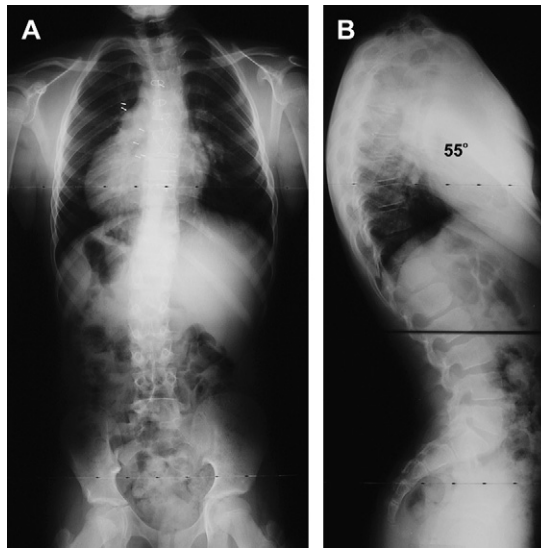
(A) Anteroposterior and (B) lateral radiographs of a patient with postural kyphosis demonstrate a uniform rounding of the thoracic spine without vertebral or disc abnormalities.
